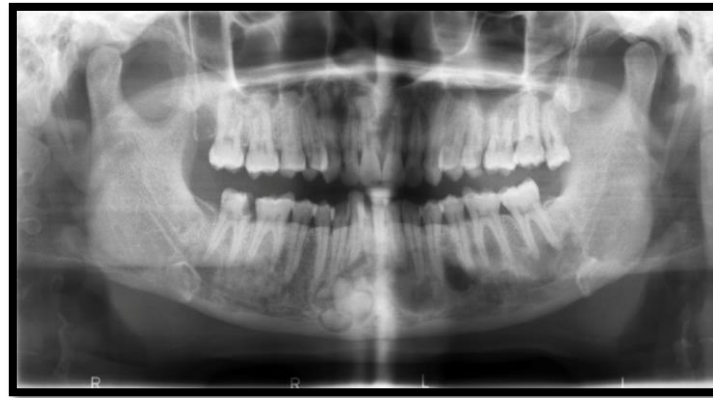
Orthopantomogram Image Showing Multiple Ill-Defined Radiopacities in All the Quadrants of Both the Jaws and a Well Defined Radiopacity in the Anterior Mandible Surrounded by Irregular Radiolucent Border.
